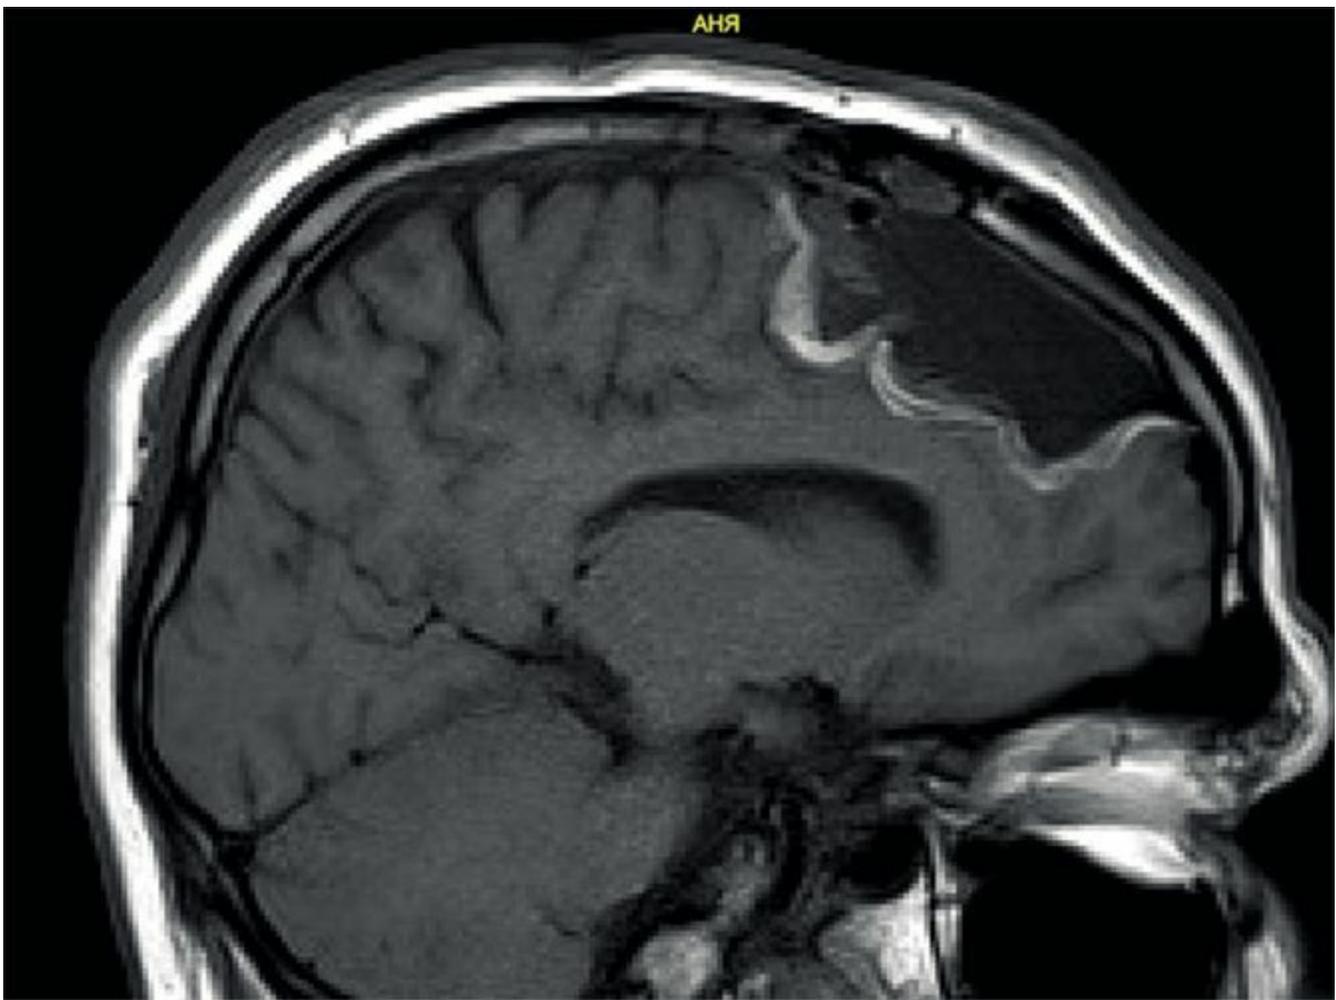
Immediate postoperative MRI.
